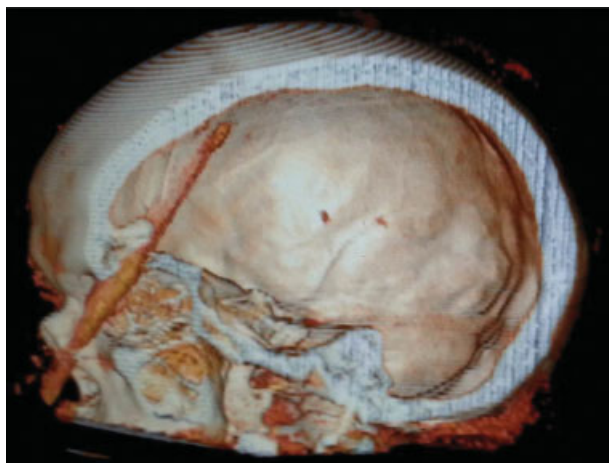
Computed tomography with three-dimensional reconstruction showing the passage of the wooden twig.
